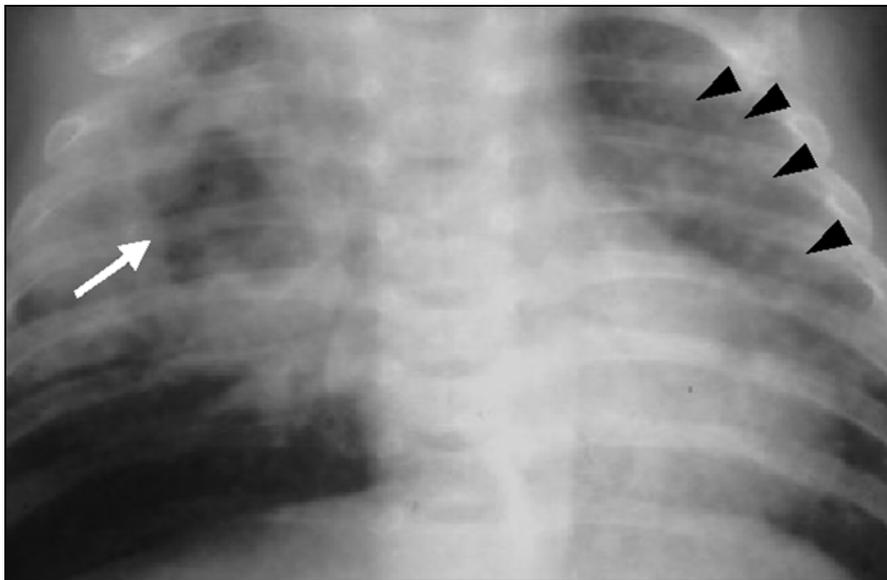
6-month-old boy with pulmonary tuberculosis (patient 10). Large cavity within consolidation. Chest radiograph shows large cavity within consolidation in right upper lobe (*arrow*). Multiple nodules are seen in left upper lung field (*arrowheads*).
